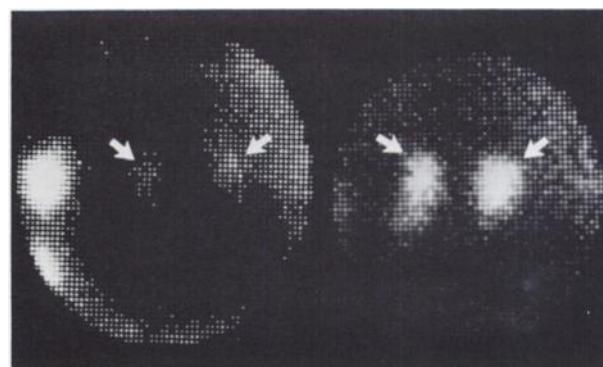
Posterior adrenal scintigrams on Day 5 (with 10% background subtraction) in two patients with Cushing's disease. Patient at left had serum cholesterol 390 mg/dl, total adrenal NP-59 uptake of 0.23% (normal 0.33 ± 0.07%) (7), and urinary free cortisol 1159 µg/day (normal 30–150 µg/day). Patient at right had serum cholesterol of 200 mg/dl, NP-59 uptake of 0.78%, and urinary free cortisol 1950 µg/day. Arrows indicate adrenals, with liver activity overlying right adrenal and bowel activity below left adrenal.
